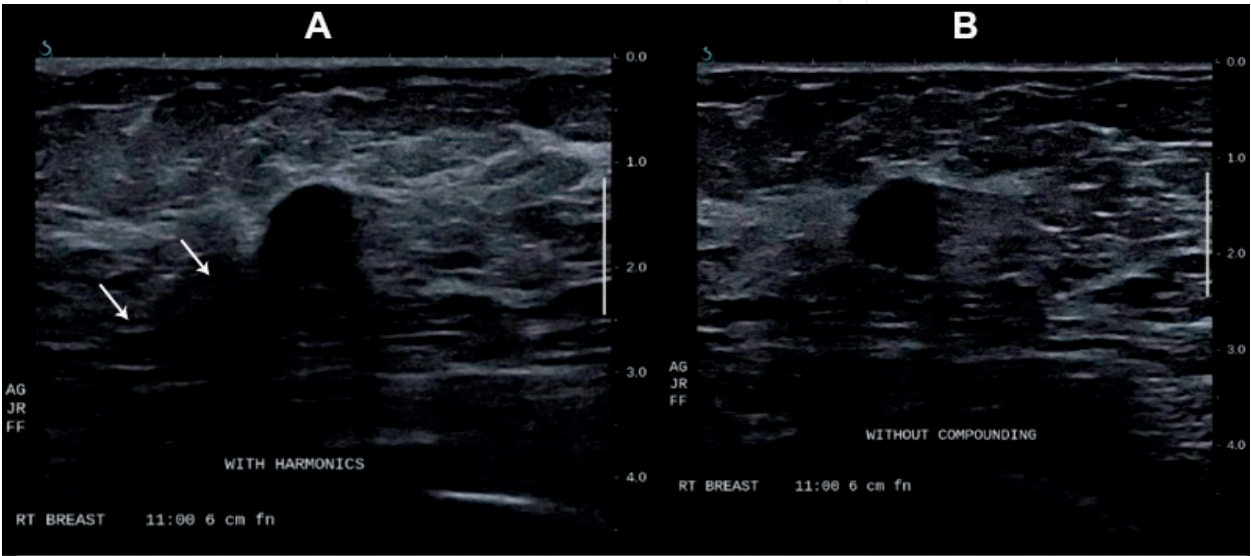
Harmonics increase real echoes. Transverse ultrasound of the right breast shows harmonics increasing real echoes. (A) With harmonics and (B) without harmonics.
